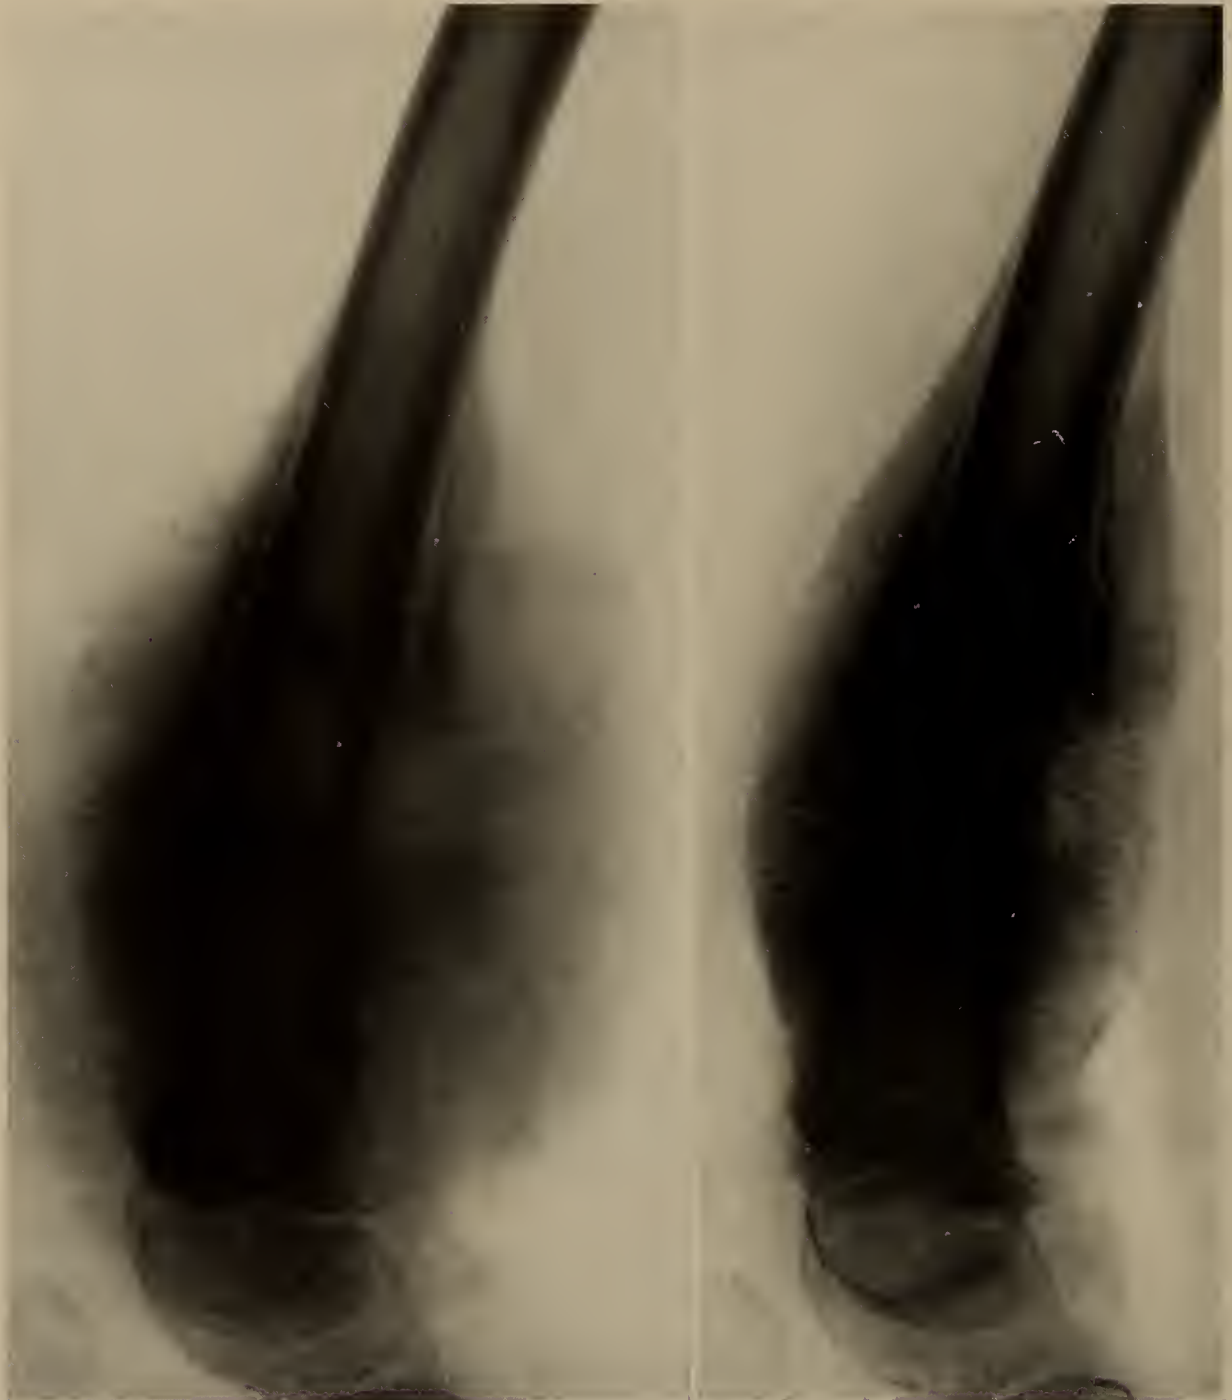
Personal observation; not registered. Osteogenic sarcoma in a boy 5 years old. Death 9 months after the onset. Showing the response of the tumor to radiation. Between the two roentgenograms an interval of 3 weeks has passed, during which time the patient was given 3 half hour exposures to 200,000 volts of roentgen rays.
